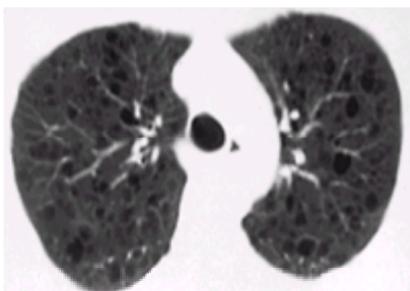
Lymphangioliomyomatosis of lungs imaged with high-resolution computed tomography showing typical cystic spaces.
